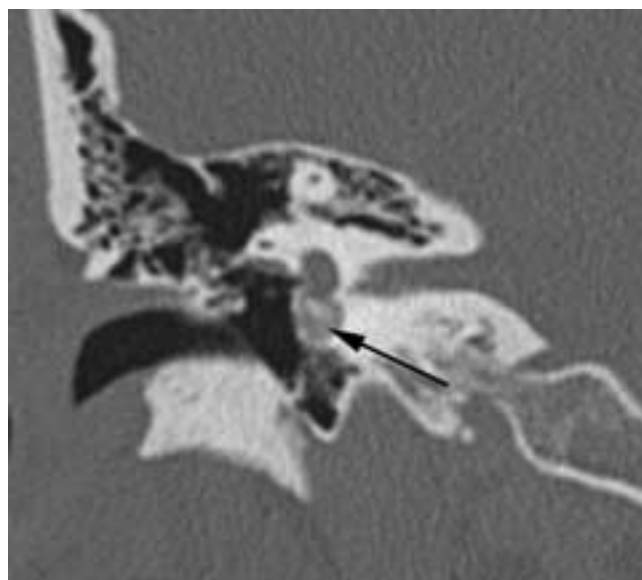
Otosclerosis, round window obliteration. Coronal CT image demonstrates prominent overgrowth of the demineralized, otosclerotic plaque obstructing the round window (*arrow*).
